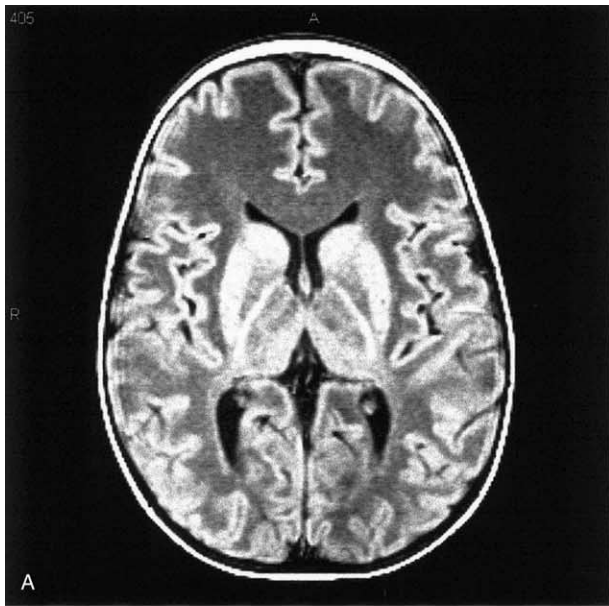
Magnetic resonance imaging at the initiation of treatment with lithium citrate (A) and at 3 months (B) and 4 months (C) of lithium citrate treatment.
